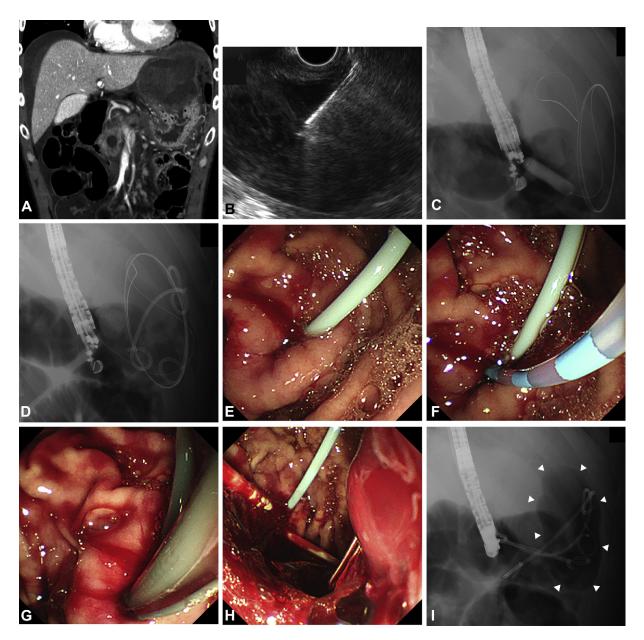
A, Coronal section of a contrast-enhanced CT image showing pancreatic walled-off necrosis with spontaneous rupture located around the stomach. B, EUS view showing an aspiration needle punctured into the pancreatic necrotic cyst. C, Fluoroscopic view showing that a fistula of the stomach and the pancreatic necrotic cyst was dilated using a dilation balloon catheter. D, Fluoroscopic view showing only the nasocystic catheter from the fistula without the plastic stents; migration of the stents into the pancreatic necrotic cyst was suspected. F, Endoscopic view showing the tip of a cannulation catheter directed to the fistula to pass a guidewire into the fistula. G, Endoscopic view showing that a snare was inserted into the pancreatic necrotic cyst alongside a nasocystic catheter through the fistula. H, Endoscopic view showing the nasocystic catheter and 2 plastic stents from the fistula. I, Fluoroscopic view showing the 2 successfully recovered plastic stents and the nasocystic catheter for transgastric drainage of the pancreatic necrotic cyst (*arrowbeads*).
